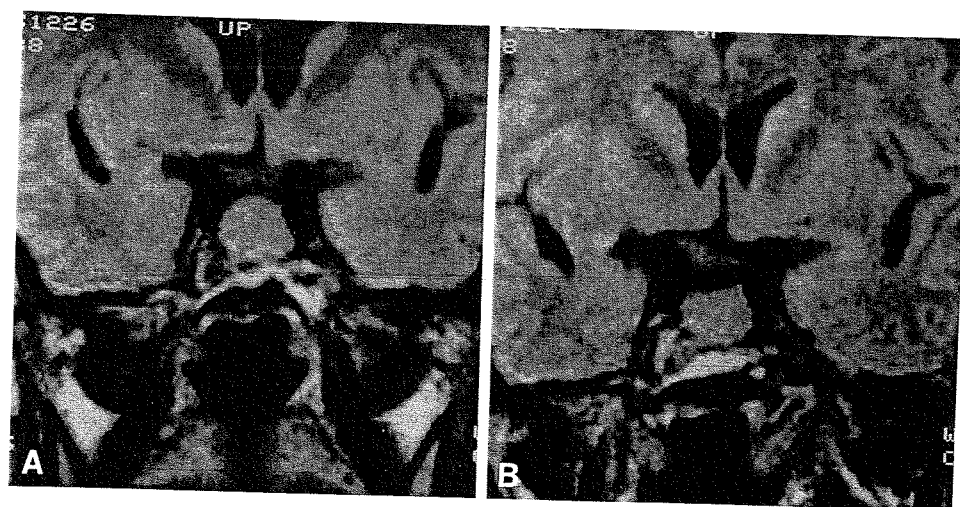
Frontal T₁-weighted MR imaging of pituitary region in a patient (no. 6) with a TSH-secreting pituitary adenoma treated with octreotide (A, before treatment; B, after 6 months of treatment).
